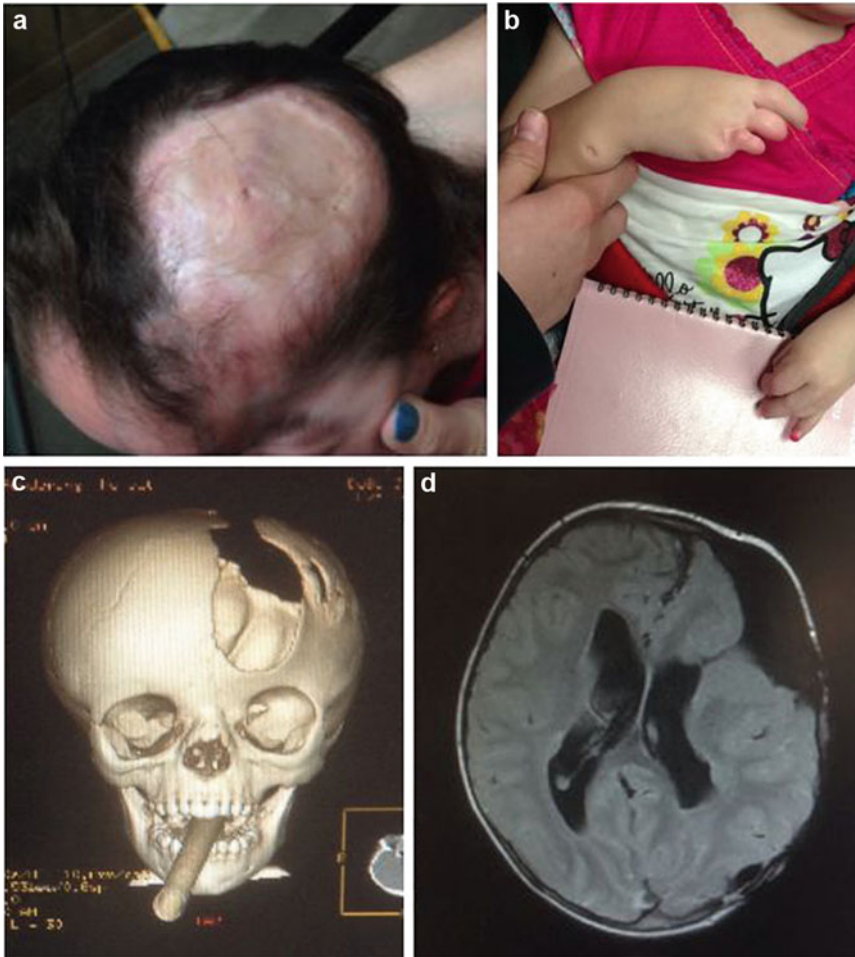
This 3-year-and-7-month-old girl was evaluated for scalp defect (a) and terminal transverse limb defect (b). CT of the craniofacial bones (c) showed a large calvarial defect overlying the left frontal and parietal bones. MRI of the brain without contrast (d) showed a prominent axial cystic collection overlying the left frontal lobe directly overlying the schizencephaly, most
